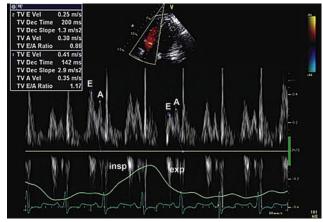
CP: apical 4-chamber view of the tricuspid inflow with PW Doppler in a patient with CP. Measurements of peak E-wave velocity in inspiration and expiration are made, similar to Figure A20. However, respiratory variation from expiration is determined by the formula (expiration – inspiration)/expiration or, in this example, (21-41)/21=-95%. A >40% respiratory variation of tricuspid inflow is considered consistent with CP. Similar to mitral inflow respiratory variation, maneuvers may be required to demonstrate to demonstrate respiratory variation.
